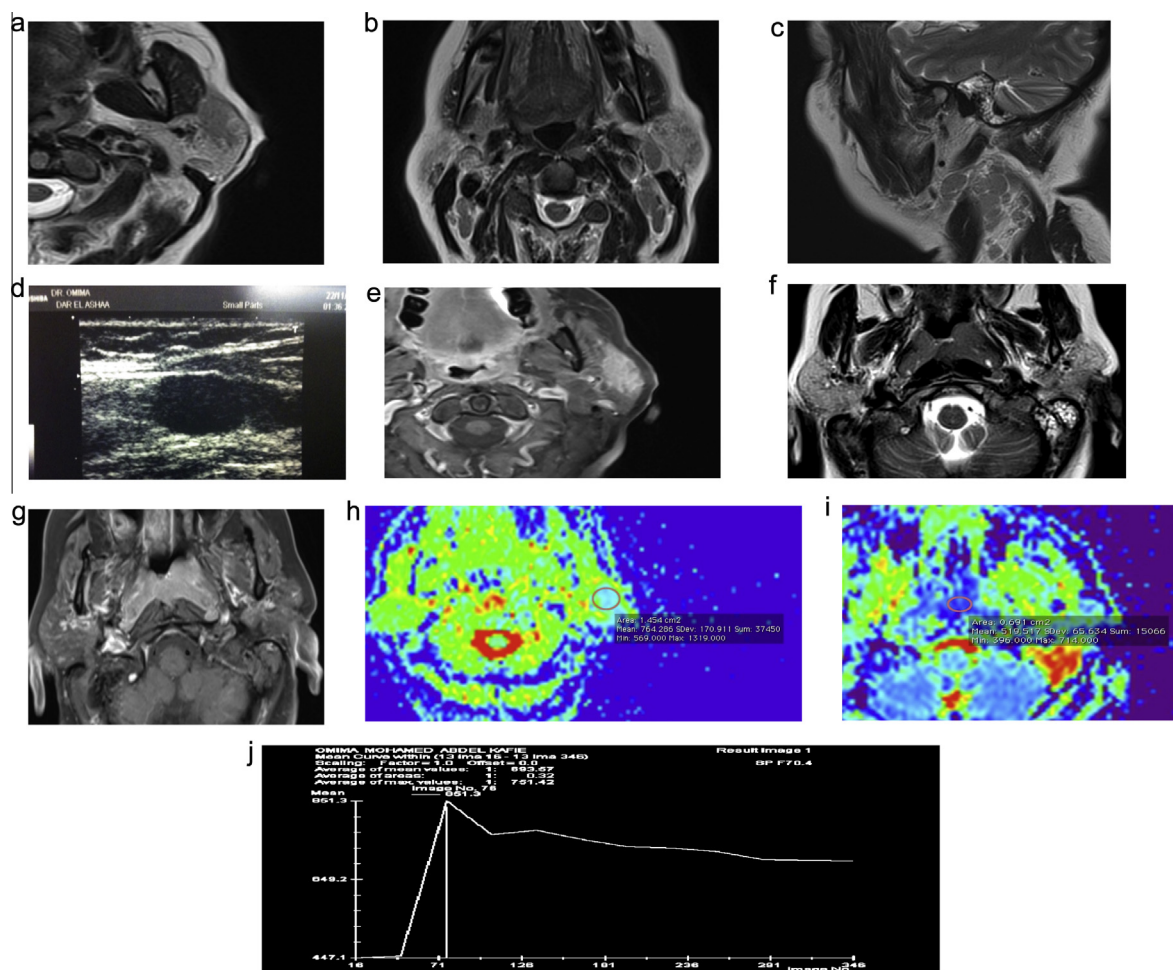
Case 6: Non-Hodgkin lymphoma. A 60 years old female presented with bilateral cervical neck swellings and left peri-auricular swelling slowly growing over several months. Axial T2 images in (a and b) showed ill defined hypo-intense lesion located in the left parotid in (a) and bilateral deep cervical lymph nodes shown in sagittal T2 image in (c). Ultrasound image of the node (d) revealed marked hypo-echogenicity. Axial post GAD T1 image in (e) showed homogenous solid moderate enhancement of the lesion. Axial T2W in (f) showed asymmetrically prominent nasopharyngeal tissue on left side expanding left fossa of Rosenmüller. This exhibited hypo-intense signal with homogenous moderate post GAD enhancement. (g) Color scale ADC maps showed low ADC value obtained from parotid lesion and cervical nodes (h and i). (j) Revealed high washout ratio suggested by Type-B curve. *Conclusion* was made of Lymphoma of nodal and extra-nodal lymphatic tissues (Nasopharyngeal adenoid and left parotid). Confirmation was later made by nodal Biopsy which revealed non-Hodgkin lymphoma.
